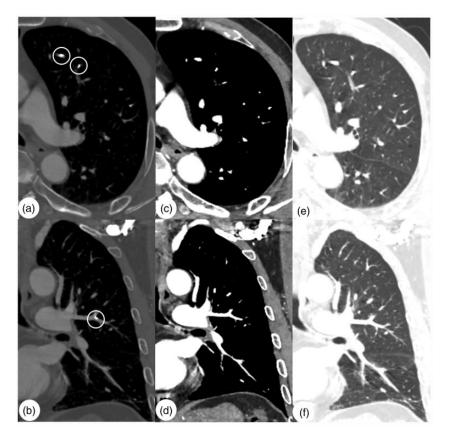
(a, b) Selected axial and coronal images of the bone window settings on chest computed tomography showed several small nodular or linear hyperdense cement emboli (circles) in the pulmonary artery branch in the left upper lobe. Images obtained using the (c, d) soft tissue window and (e, f) lung window settings on chest computed tomography showed no evidence of cement emboli.
